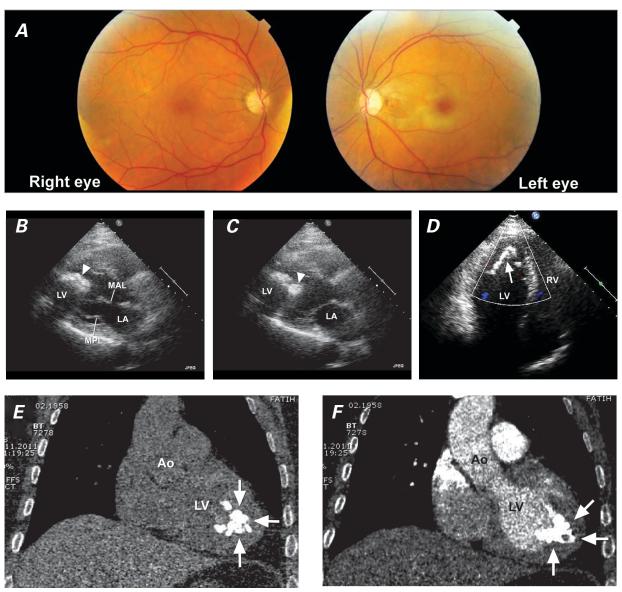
A) Fundus photography shows a cherry-red spot with retinal pallor typical of central retinal artery occlusion in the left eye and a normal right eye. In the B) diastolic phase and C) systolic phase, a transthoracic echocardiogram (parasternal long-axis view) shows a mobile calcified mass (arrowhead) in the left ventricle. D) A transthoracic echocardiogram (apical 4-chamber view) shows a hyperechoic calcified mass (arrow) originating from the anteroapical and septoapical region of the left ventricle. Computed tomograms (coronal oblique views) E) with and F) without contrast material show an echogenic intracavitary irregular mass (arrows) attached to the apex of the left ventricle.
